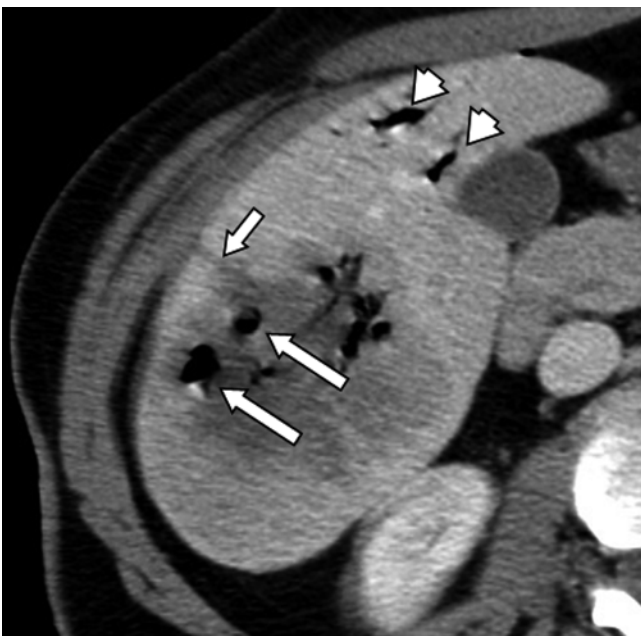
A 42-year-old female patient with metastatic melanoma to the liver. Immediate post-procedure CT image after RFA demonstrates multiple air bubbles secondary to necrosis induced by RFA (*large arrows*). Note the needle tract extending from the ablation zone to the liver capsule (*small arrow*). There is also air in the biliary system secondary to the intervention (*arrowheads*)
